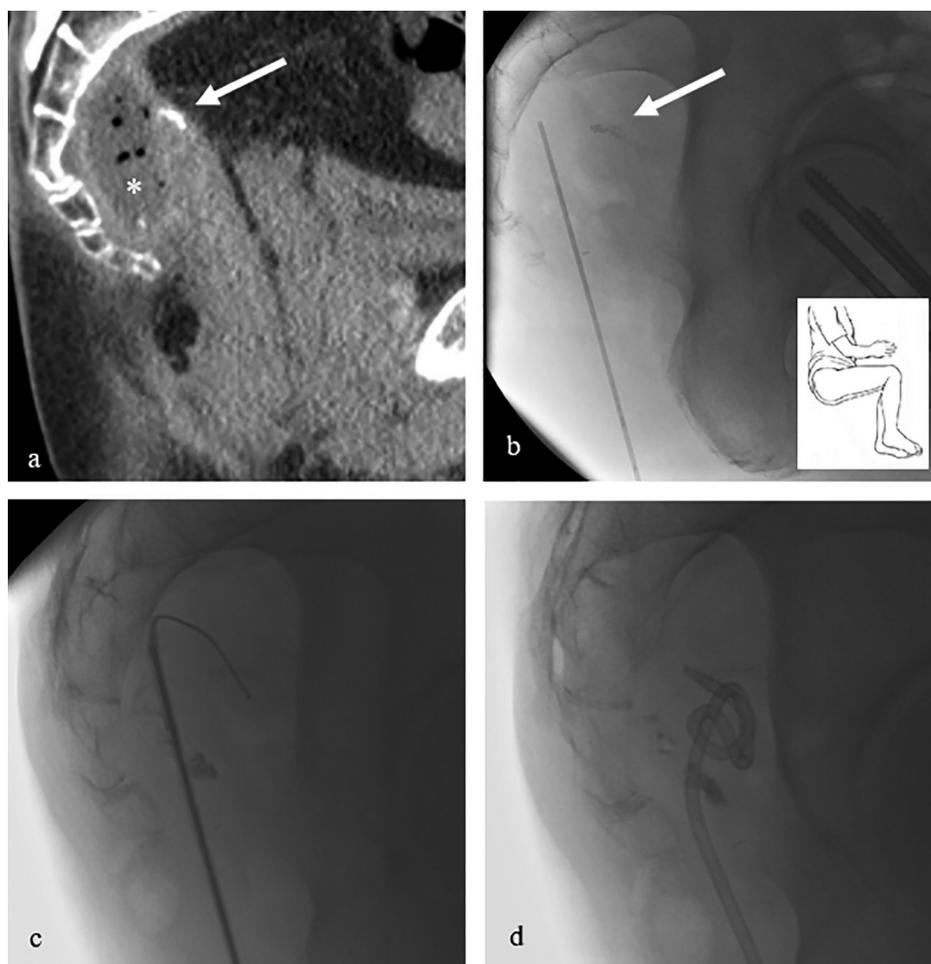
A 57-year-old man who underwent a low anterior resection. Two months earlier, he underwent CT-guided transgluteal drainage of presacral abscess. Now, he presents with fever caused by a relapse of the abscess: a: preprocedural CT image in the sagittal plane shows presacral abscess with internal gas (white asterisk) adjacent to the staples at the rectal stump (white arrow). The abscess is in the midline directly anterior to the sacrum, with no structures between the sacrum and the abscess; b: fluoroscopic image during transperineal puncture shows the needle pointing towards the abscess, the staples (white arrow) being used as landmarks. Subsequently, pus was aspirated; c: a guidewire is placed through the needle, easily curling in the fluid collection; d: over the guidewire, the locking pigtail catheter is positioned in the abscess.
